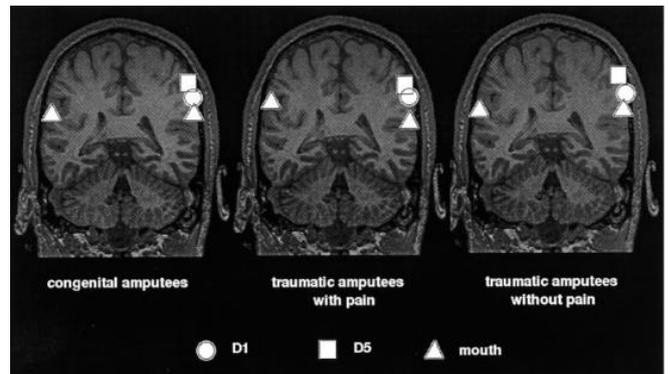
MR image comparing the cortical representation in different amputees[14]
